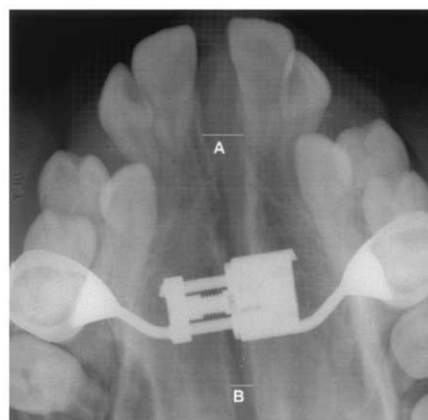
Radiographic measurement of expansion.
